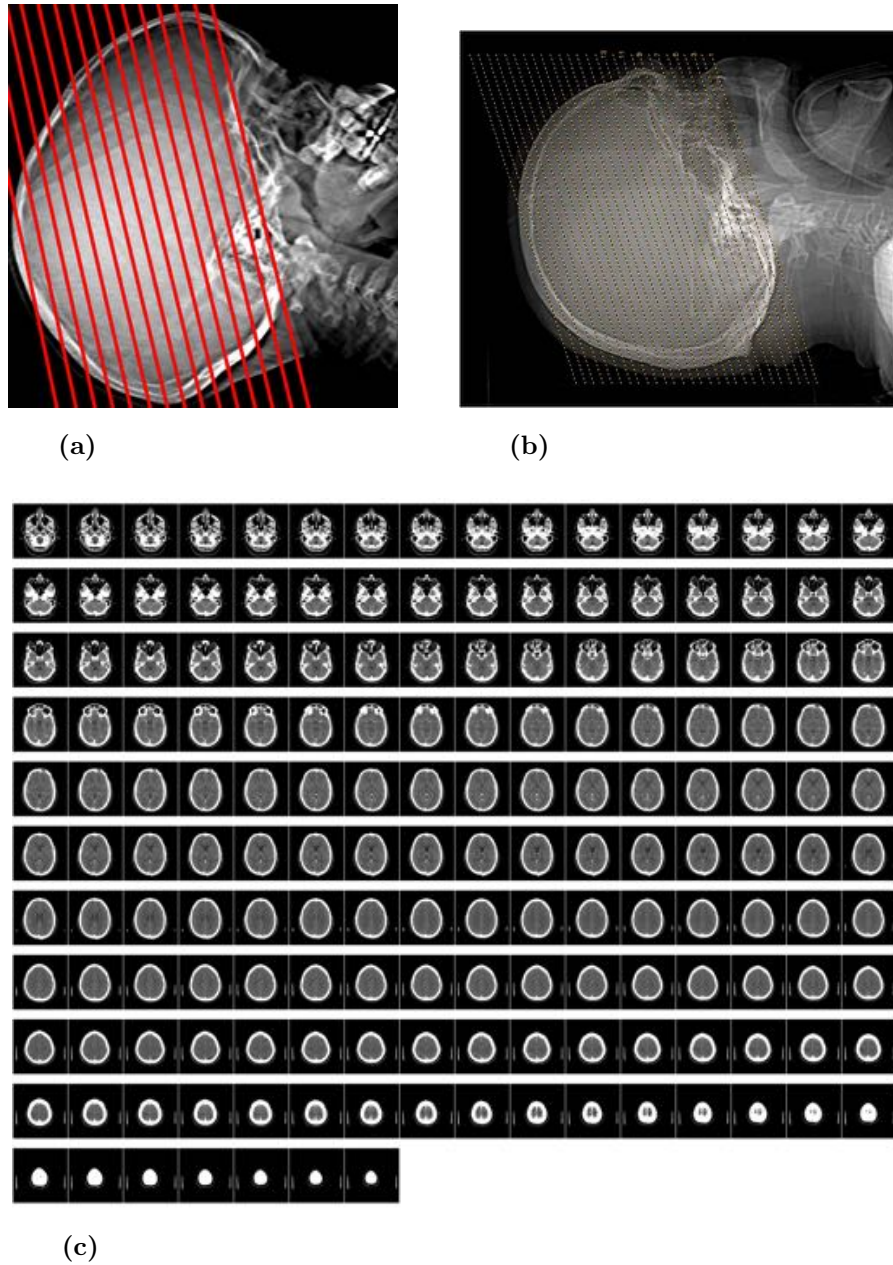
Typical CT scan procedure for brain. Images (a) and (b) represent the X-Ray scout images of the head that is to be scanned. The scout serves as a guide for the technologist indicating where to start and stop scanning ([University of Virginia 2014](#), [University of Wisconsin 2014](#)). Image (c) is the typical CT study of brain performed for assessment.
